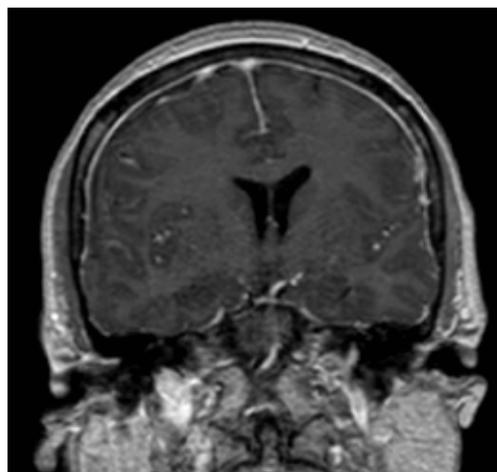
Coronal T1-weighted section of the brain MRI with intravenous gadolinium showing diffuse and thick pachymeningeal enhancement.
